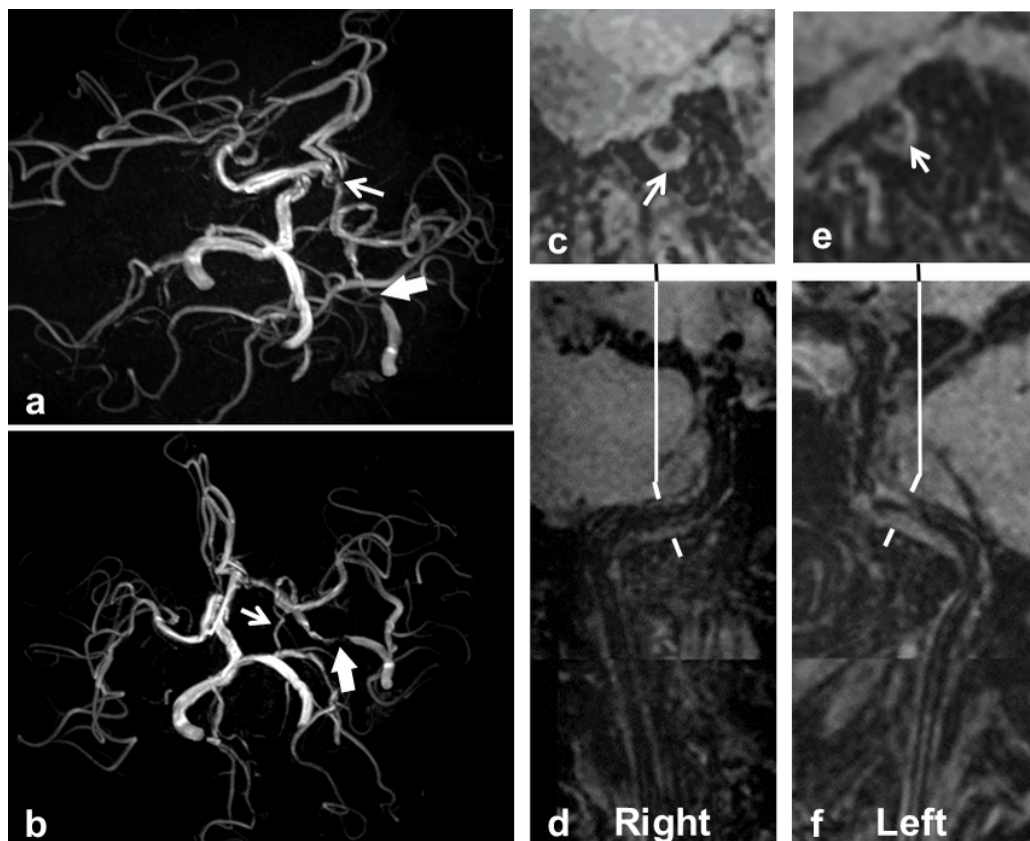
MR images of a 60-year-old man with severe intracranial artery stenosis who also had an anterior and posterior communicating artery (ACoA and PCoA, respectively). (a) and (b) represent the MIP images of TOF MRA. ACoA and left PCoA are present (thin white arrows in a and b), and severe stenosis in the C2 segment of the left internal carotid artery was observed (thick arrows in a and b). (d) and (f) represent the curved reconstructed images of MERGE. Two plaques in the C2 segments of the bilateral internal carotid arteries (arrows in c and e) are shown.
